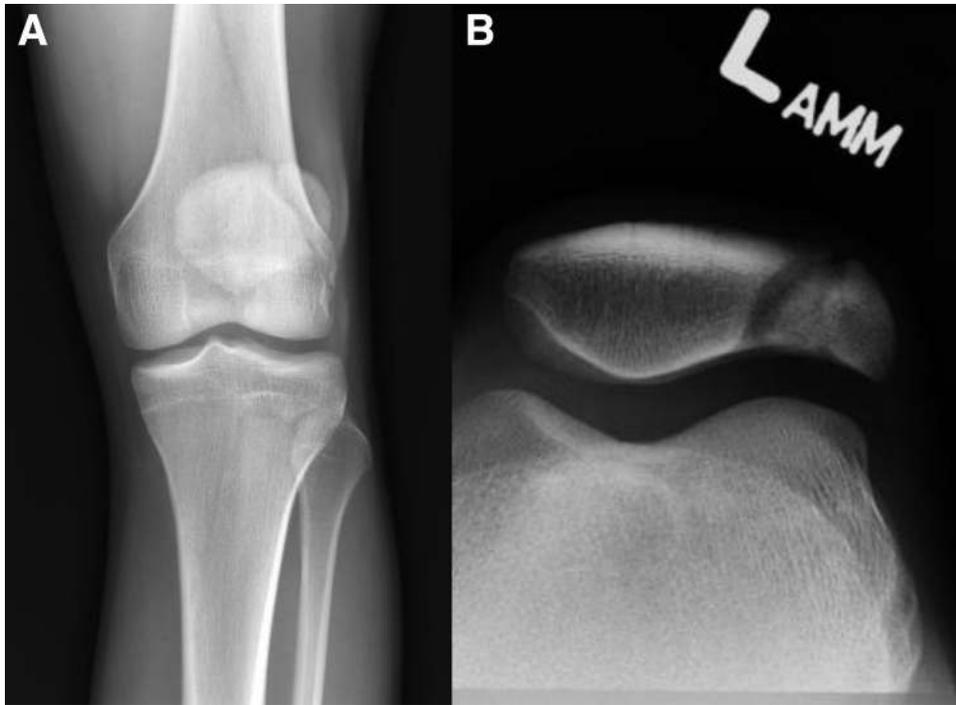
Anteroposterior (A) and sunrise (B) radiographs showing a bipartite patella in a right knee. The bipartite patella develops from an accessory ossification center in the patella—sometimes more than one. Typically, this developmental abnormality is asymptomatic and is discovered incidentally. However, in a minority of patients, pain over the superolateral, lateral, or inferior aspect of the patella and pain with activity may be caused by irritation. (A) Anteroposterior radiograph showing a patella with a superolateral fragment connected to the main body of the patella by a radiolucent band. (B) Sunrise view of same knee. The accessory patellar fragment can be seen extending far laterally, with a projection extending over the lateral femoral condyle. The arrows indicate the accessory portion of the bipartite patella. L, left.
